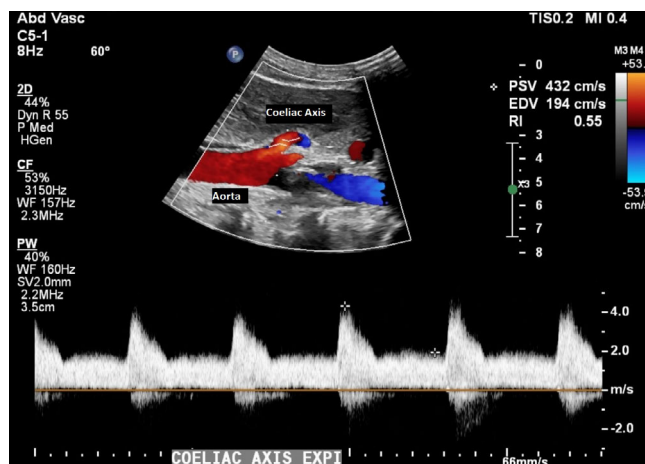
Spectral Doppler trace of the Coeliac Axis Origin during expiration.
